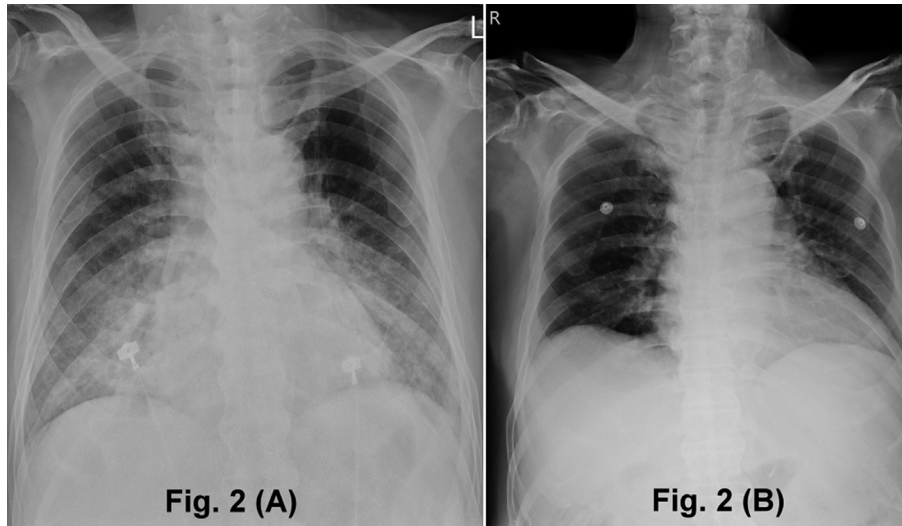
Case 2: chest radiograph showing features of bilateral alveolar edema at presentation (A) and resolution of pulmonary edema after treatment with nitroglycerin and hemodialysis (B).
